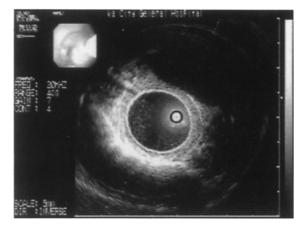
Ultrasound image obtained with the EU-M2000.
